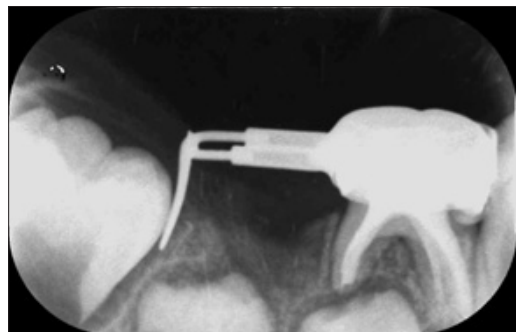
Immediate post operative radiograph with distal shoe space maintainer.
